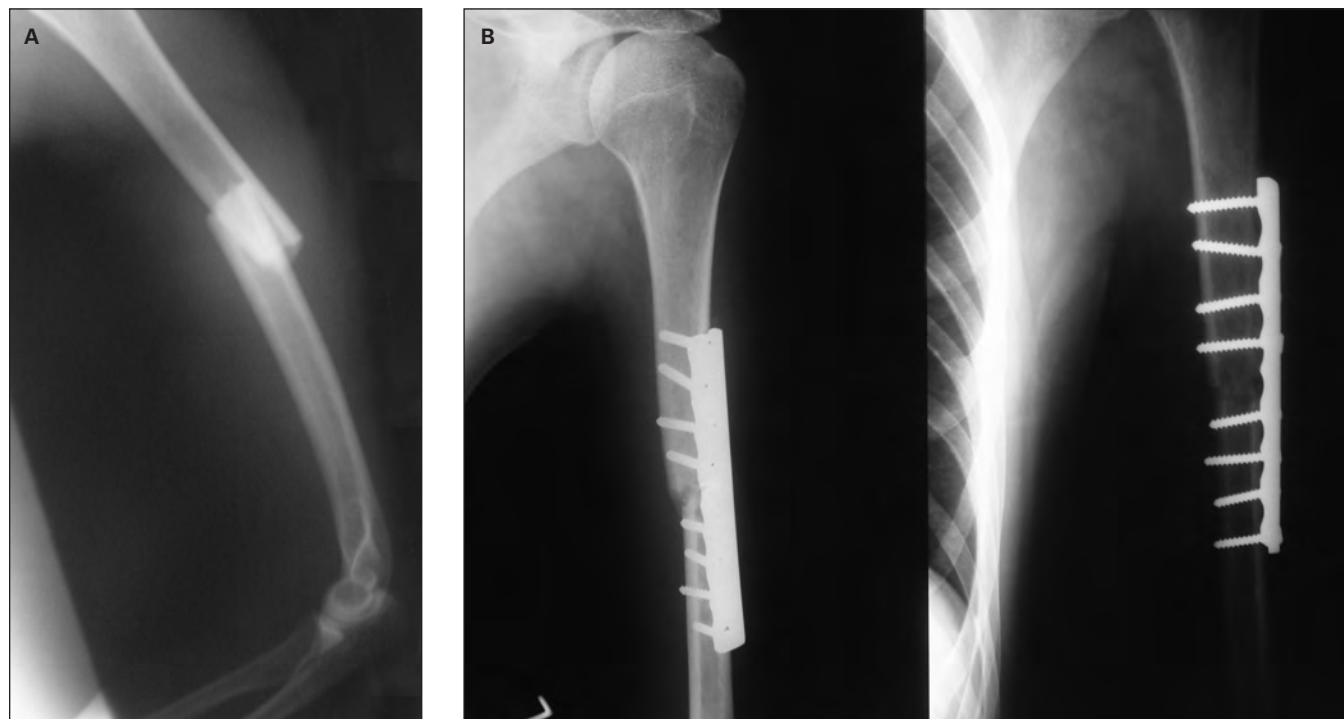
(A) Pre- and (B) postoperative radiographs of a humeral shaft fracture.
